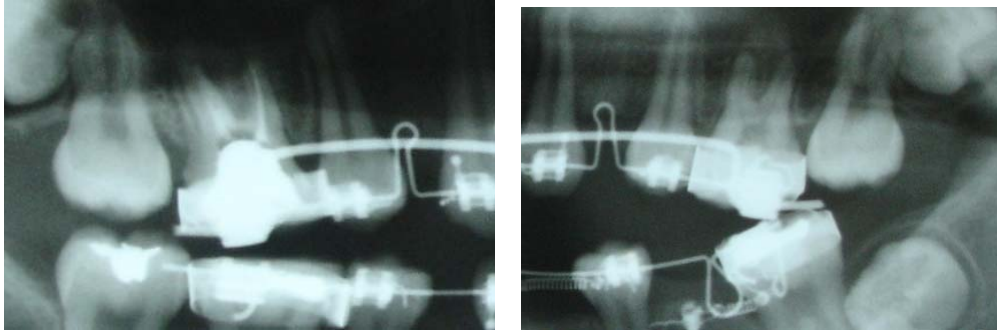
Case1: Radiographs showing mesial tipping of upper right (A) and left (B) first molars.
